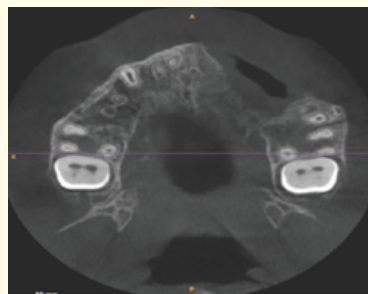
CT shows the amount of defect.
